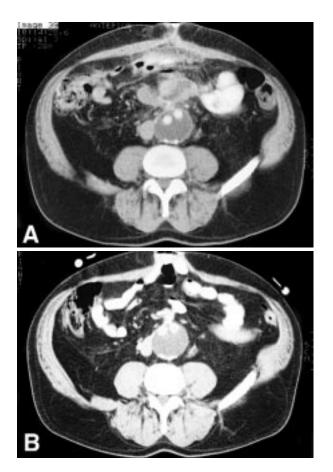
Follow-up CT scans. A, Discharge CT scan. The transverse "cut" is through the window, and there are inflammatory changes anteriorly. B, Resolution of the inflammatory changes with slight reduction in the size of the sac demonstrated by means of a CT scan 10 months postoperative.
